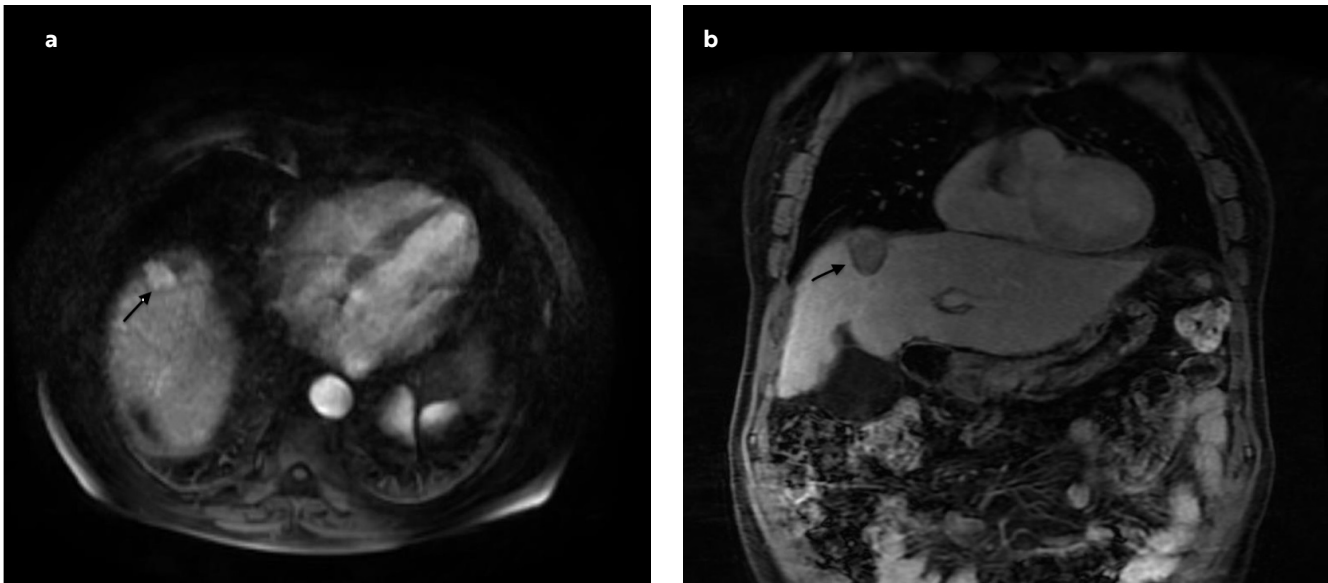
a. Pre-ablation axial contrast-enhanced T1W magnetic resonance imaging (MRI) demonstrates diffuse homogenous contrast enhancement in HCC adjacent to the diaphragm. b. There is no contrast enhancement in the coronal contrast-enhanced T1A MRI of the same patient after ablation.
